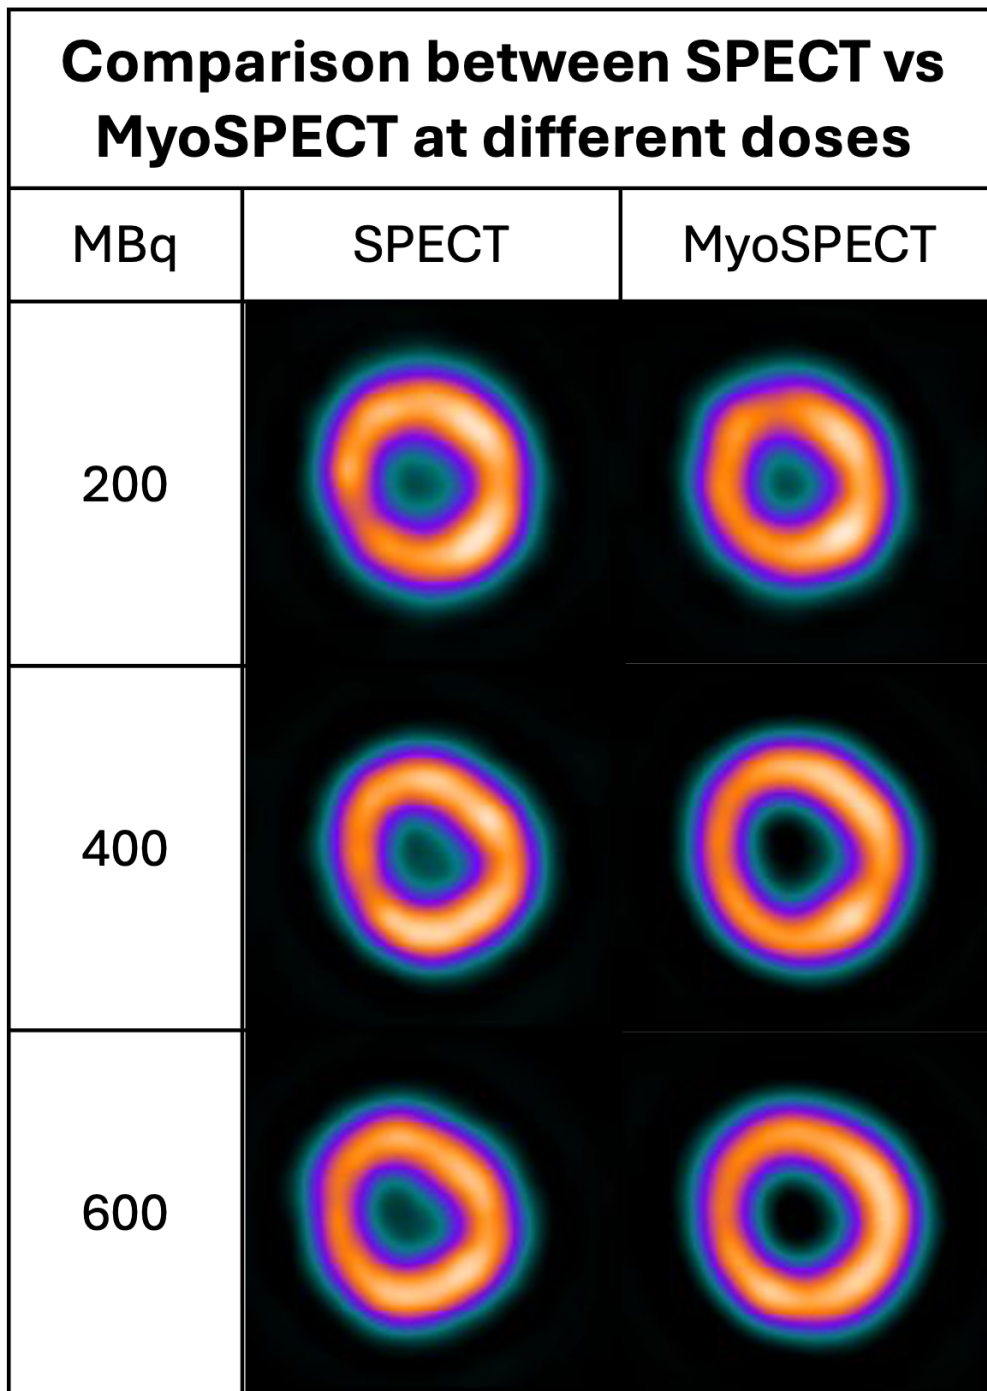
Comparison of SPECT and MyoSPECT through the SA view
